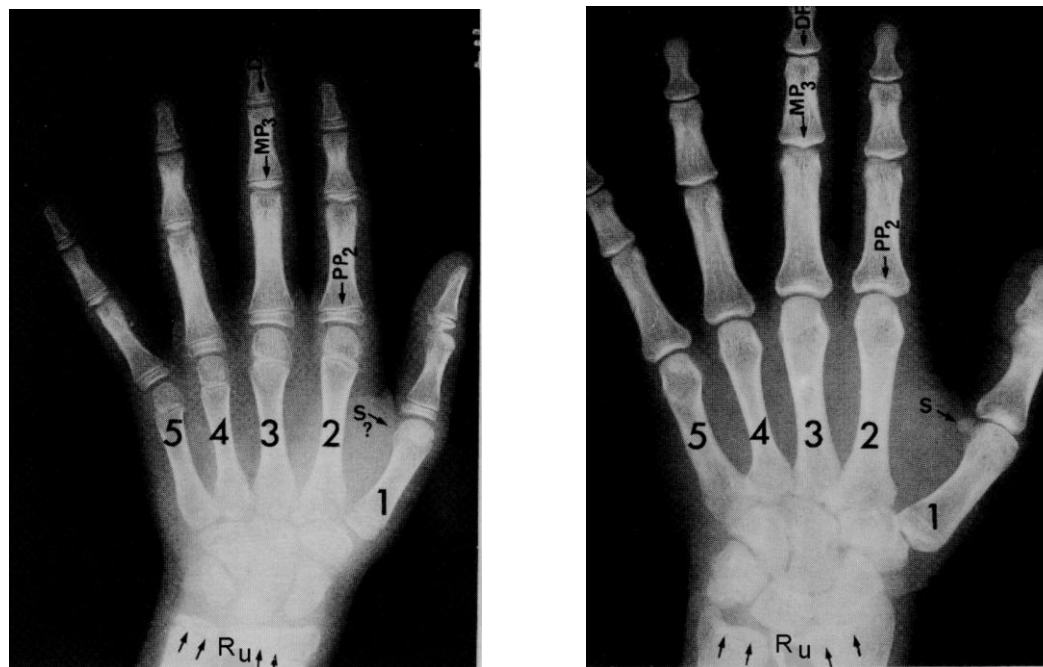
Hand wrist radiographs of an individual before the pubertal growth spurt and after completion of growth. The changes between the two provide clues for the assessment of skeletal age.
